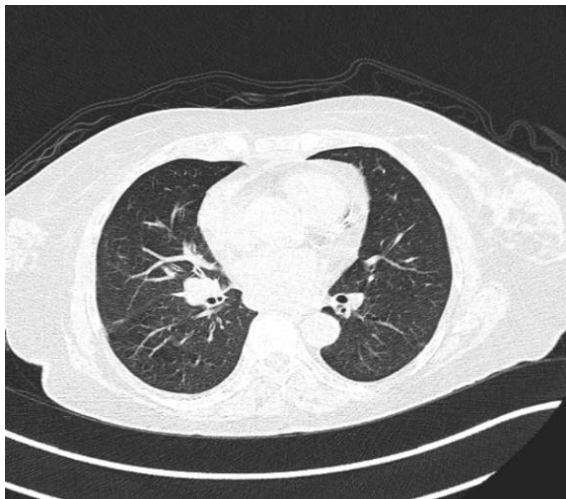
Shows the Mild Right Pleural Effusion Noted and Small Volume and Enlarged Peripherally Enhancing Hypodense Lymph Nodes are Noted in PET-CT.
